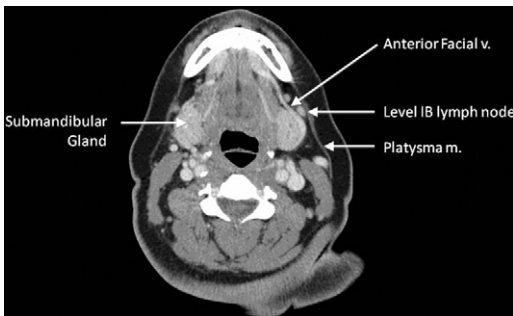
CT anatomy of the submandibular gland. Whether a mass is glandular or nodal may sometimes be difficult to determine. If the facial vein comes between the gland and the mass, the lesion is nodal.
